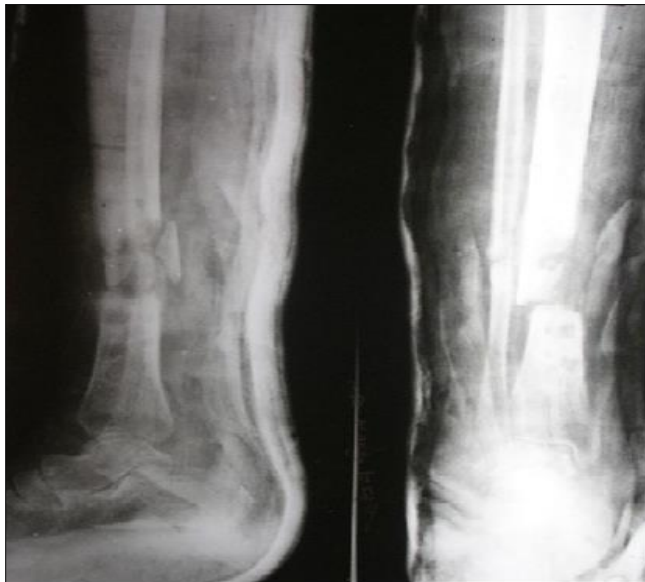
Pre-operative X-ray showing Non-union tibia.
